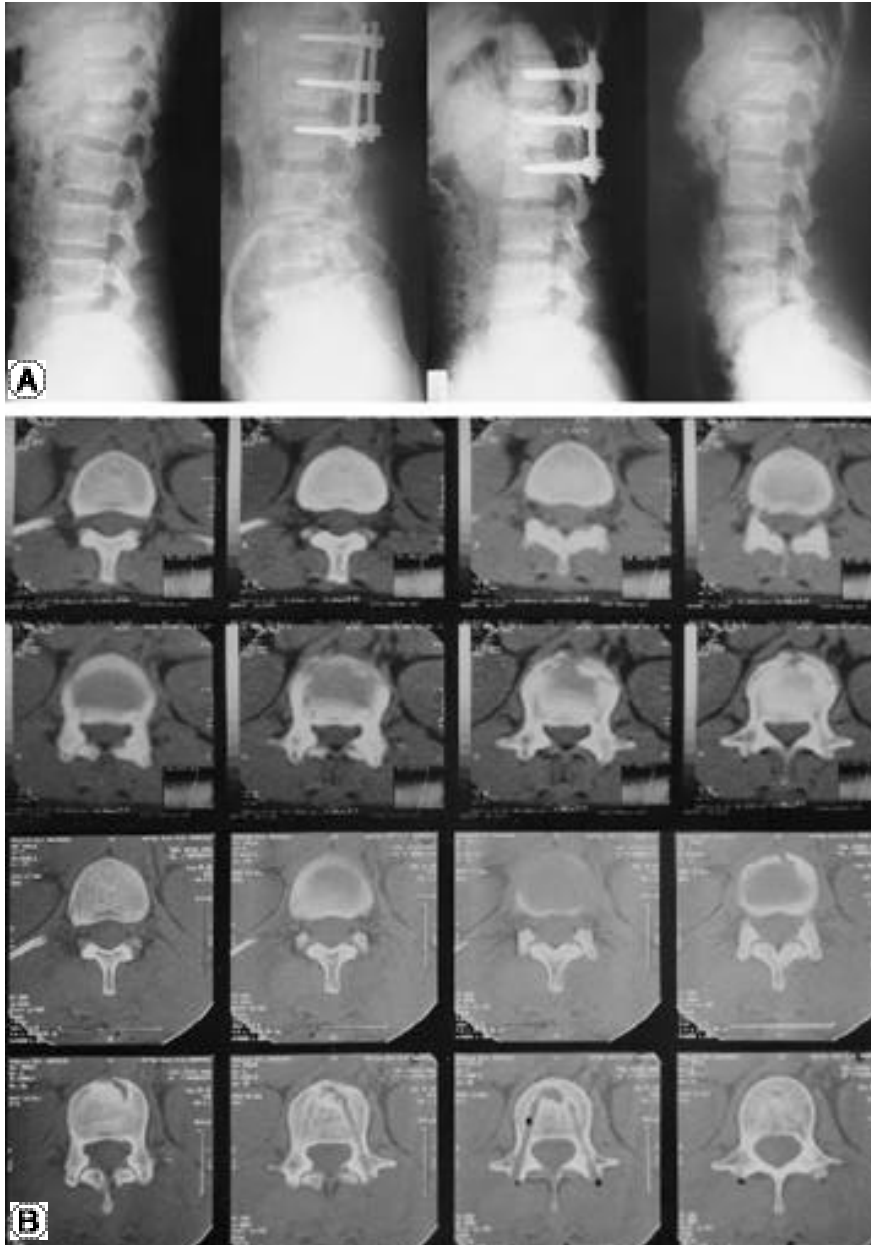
A. Case2: Simple radiograph of a 41 years old female with 48.7% compression & 20° kyphosis. From the left, at injury, at Postop., at POD 6M., at POD 1Yr. degrees of compression was 48.7%, 3%, 4%, 6% respectively. The angle of kyphosis was 20°, 6°, 8°, 11°, respectively. At POD 1Yr., the loss of reduction was 3%, and the loss of kyphosis was 5 degrees.
